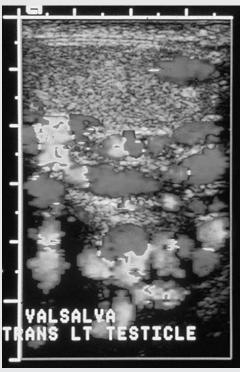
Duplex sonogram of the inferior portion of the left scrotum (see color plate 8).
